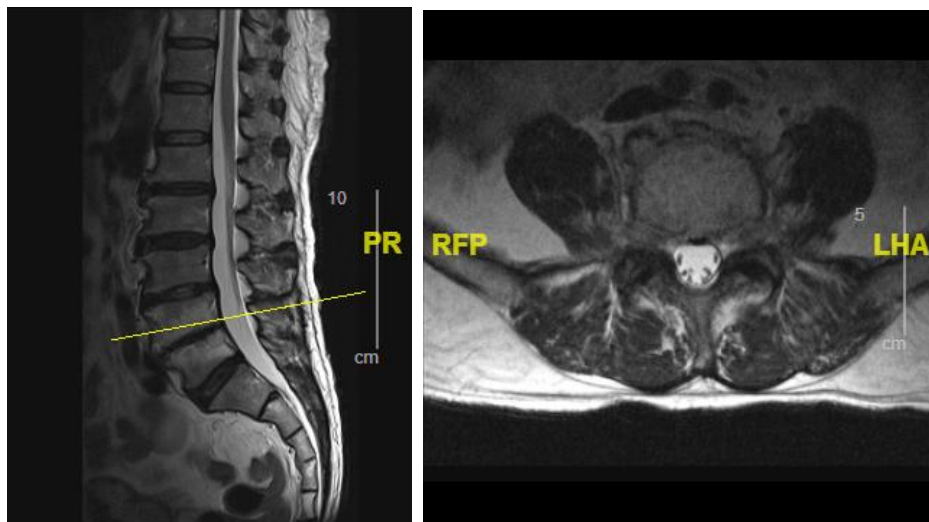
Repeated lumbo-sacral MRI after completion of treatment showing radiological improvement.
